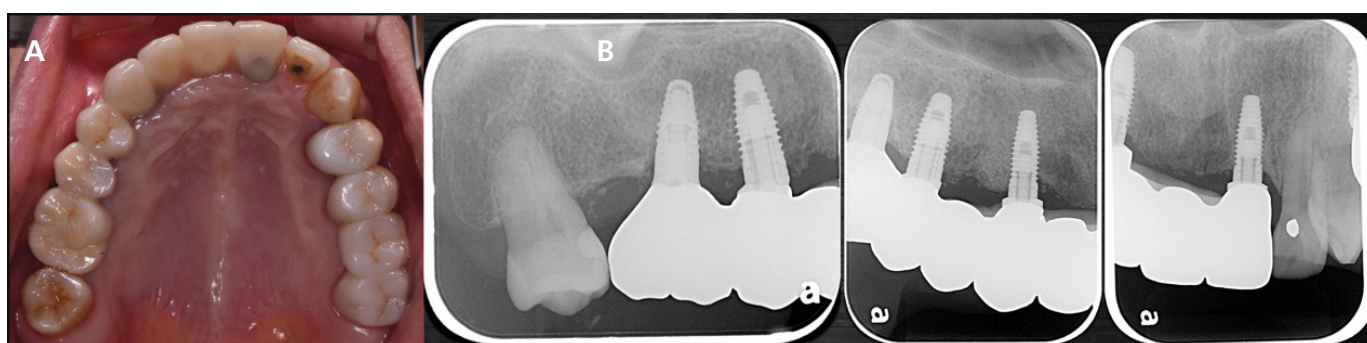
After definitive implant supported FDPs delivery. (a) occlusal intraoral view; (b) periapical film
